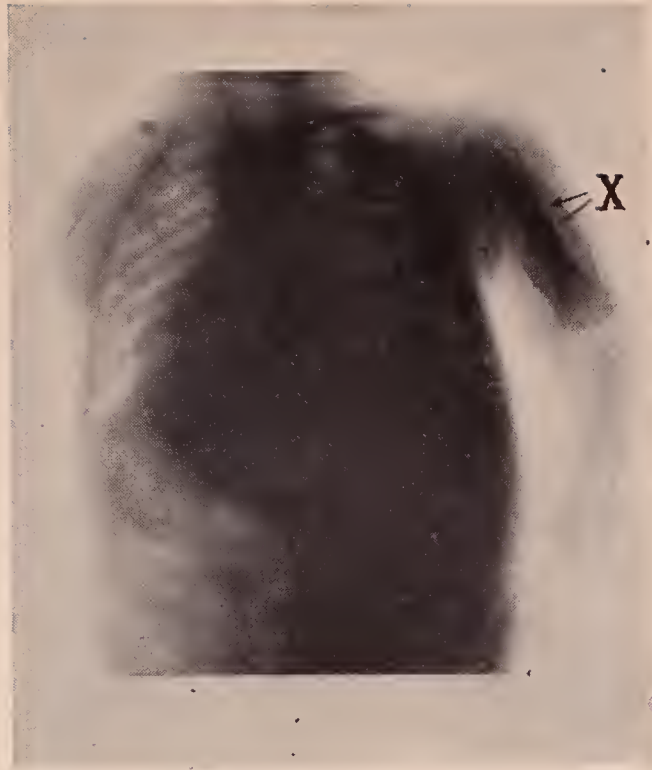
X-ray of baby, showing swelling under the periosteum of the bone at X, due to hemorrhage occasioned by scurvy. This was caused by an exclusive diet of condensed milk.
